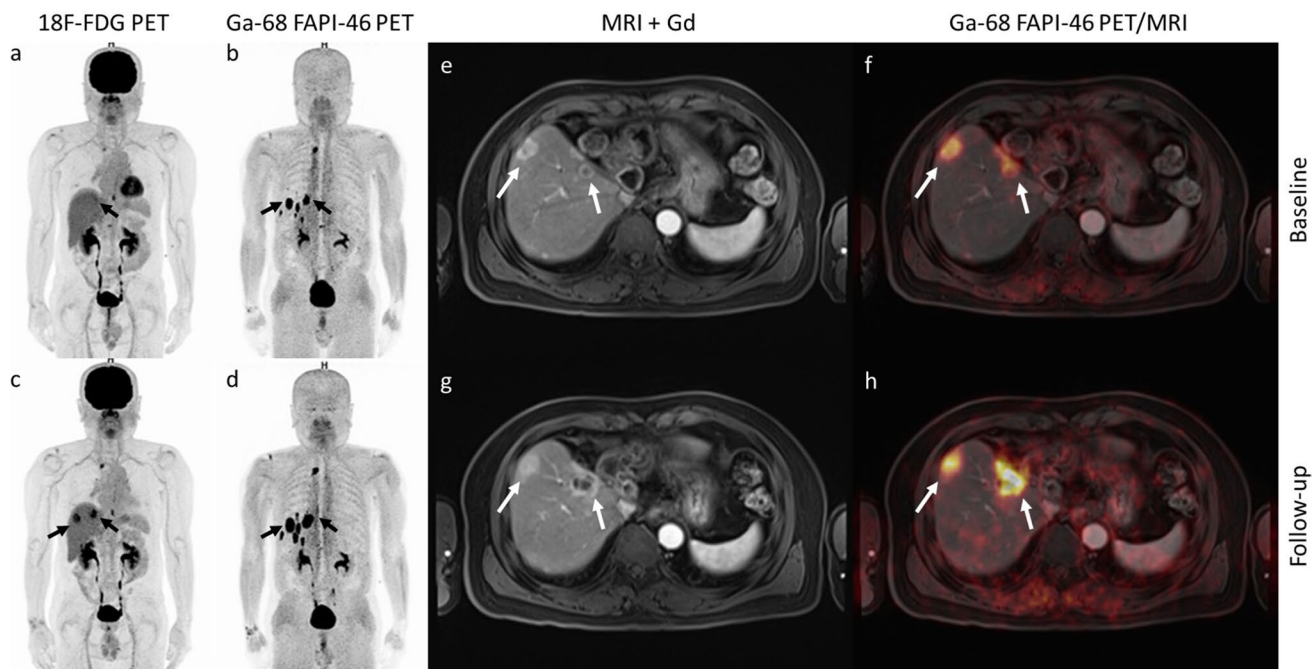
A 78-year-old man with intrahepatic cholangiocarcinoma who underwent left hepatectomy and chemotherapy approximately 3 years earlier (last chemotherapy session approximately 3 months prior to imaging). The patient underwent PET/CT with dedicated liver PET/MRI for restaging. (b) Whole-body [⁶⁸Ga]Ga-FAPI-46 PET maximum-intensity-projection (MIP) image showing multiple intense FAPI-avid nodules (arrows) in the liver corresponding to multiple heterogeneous enhancing nodules (e) with fluid restriction on axial fused [⁶⁸Ga]Ga-FAPI-46 PET/MRI of the liver (f); liver metastases were likely. (a) [¹⁸F]FDG PET MIP image showing only subtle uptake at the hepatic dome. Three months later, the patient underwent PET/CT for re-evaluation of disease: (d) [⁶⁸Ga]Ga-FAPI-46 PET MIP image; (g) axial gadolinium-enhanced MRI image; (h) axial fused [⁶⁸Ga]Ga-FAPI-46 PET/MRI of the liver. Follow-up [⁶⁸Ga]Ga-FAPI-46 PET/CT with dedicated liver PET/MRI shows that the previous FAPI-46-avid nodules in the residual liver have increased in size and intensity. (c) The paired [¹⁸F]FDG PET MIP image shows a few new FDG-avid nodules (arrows) in the liver, confirming the diagnosis of viable liver metastases in the study 3 months previous.
